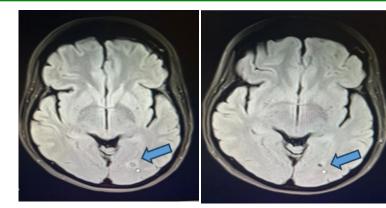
Magnetic resonance imaging of the brain which showed a 0.5x0.5cm ring enhancing lesion located in the parieto-occipital region.
